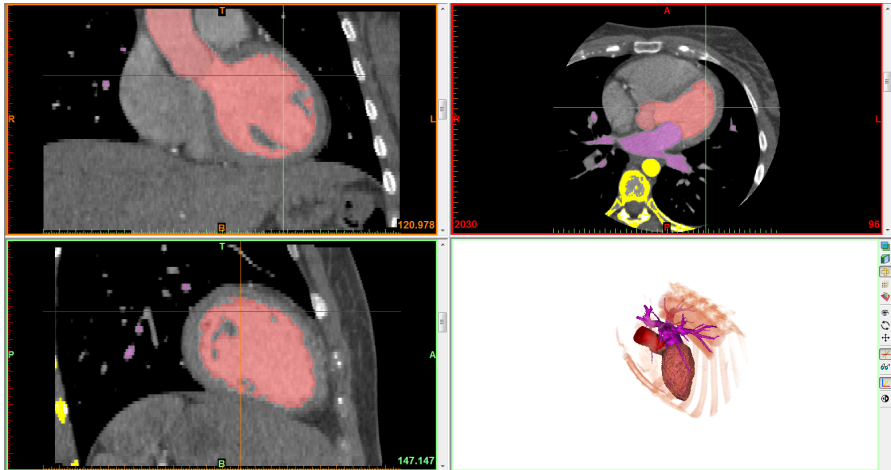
Example of CTA: screenshot from Mimics Research. Visible is three orthogonal planes of a volume of a human heart. A volume rendering is seen in the bottom right corner. A segmentation is visualized in colored surfaces. See Fig. 5.2. Modified from (Hvid 2018).
